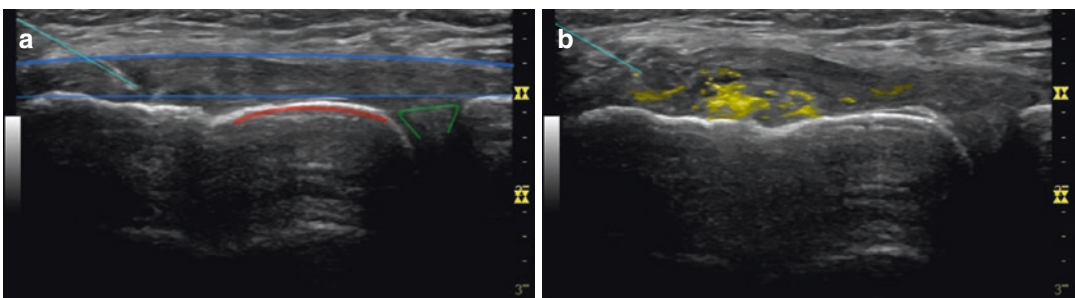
Ultrasound-guided percutaneous PRP injections into medial collateral injection. The infiltration of the ligament is performed with the ultrasound probe in the long axis, allowing to observe the ligament (blue) as well
